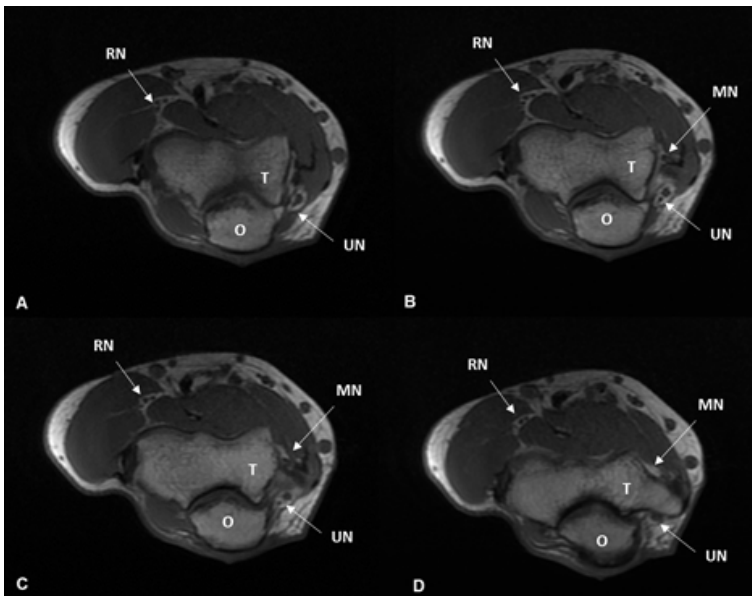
Right Elbow MRI T1 Weighted Axial Cut: ulnar nerve at different levels, going from distal to proximal (2A to 2D). It is possible to observe the bipartite ulnar nerve in a small portion of its path (2B and 2C) and then it returns to its unique configuration (2D)
